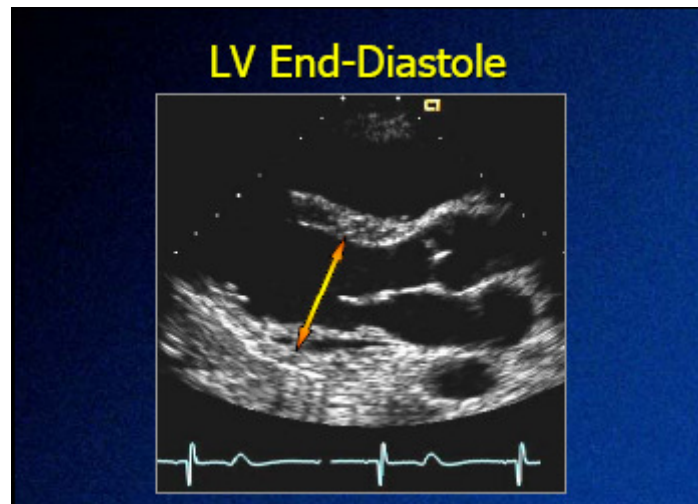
Measurement of EDD in long parasternal axis (Lang *et al.*, 2005)
